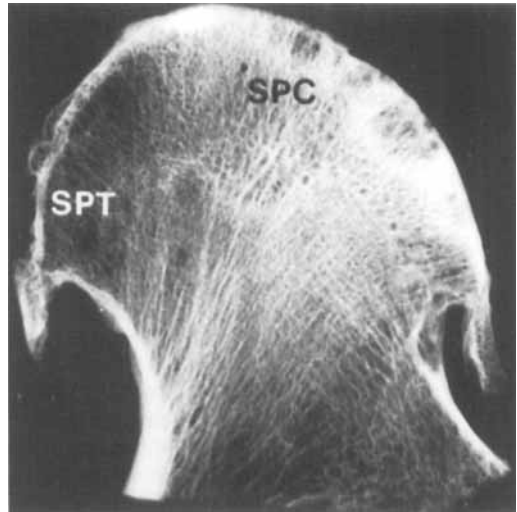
Radiograph of the central coronal slice of the femoral head showing the subchondral principal compressive (SPC) and tensile (SPT) zone examined by quantitative histomorphometry. These zones also represent the areas in adjacent slices examined for the presence of trabecular microfractures
